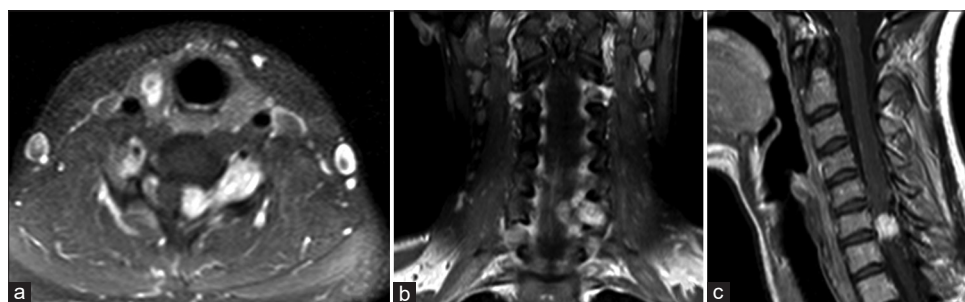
Preoperative cervical spine contrast-enhanced MRI. Axial (a), coronal (b) and sagittal (c) T1-weighted sequences: intravertebral extradural lesion, with non-homogenous contrast-enhancement, displacing contralaterally the spinal cord and extending through the left C6–C7 vertebral foramen in the extradural space, causing enlargement of the neural foramen
